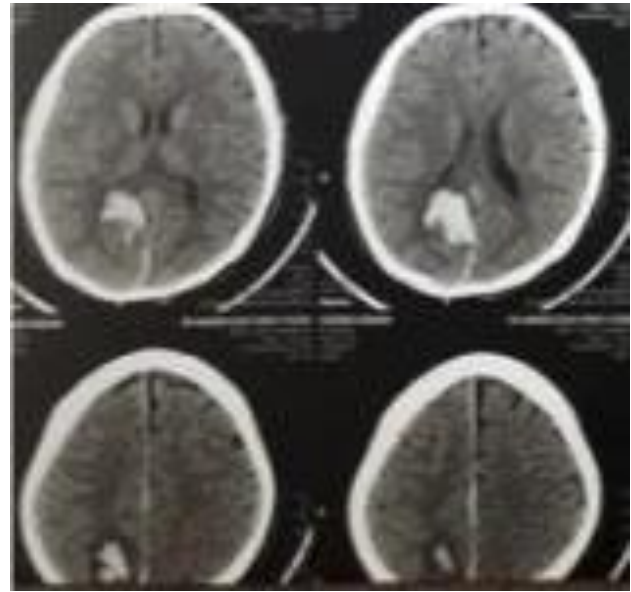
Computed tomography scan of two weeks before
